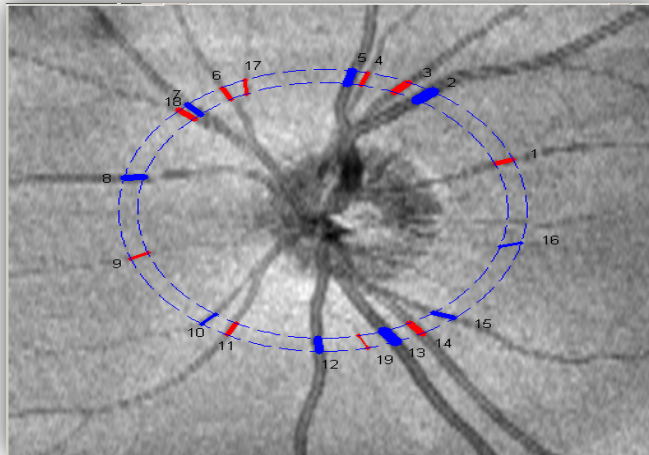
En face view of 3D OCT image showing double circular scanning protocol; the retinal vessels are labelled from 1 to 19. The red and blue color represents software identified vessel type as artery and vein respectively based on its Doppler signal.
